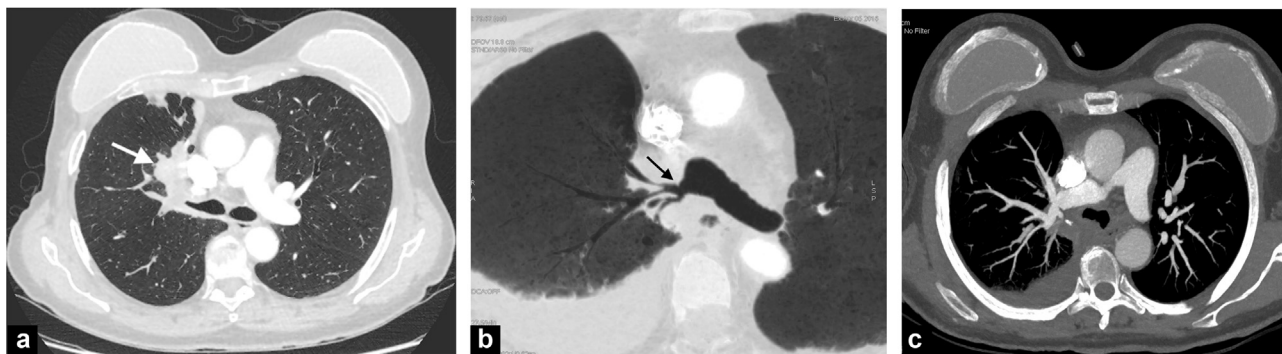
A 58-year-old patient treated for right upper lobe adenocarcinoma with extension to the main bronchus (arrow). Preoperative axial CT image in the parenchymal window after IV contrast enhancement (a). This image shows central tumor infiltration extending to the right main bronchus. Postoperative axial CT image with iodine contrast enhancement. Min IP axial reconstruction shows reinsertion of the right lower lobe bronchus into the main bronchus (b) (arrow). The MIP reconstruction shows the end to end anastomosis and interposition of a vascular graft (c). The tissue density image behind the allograft represents the presence of an intercostal flap.
